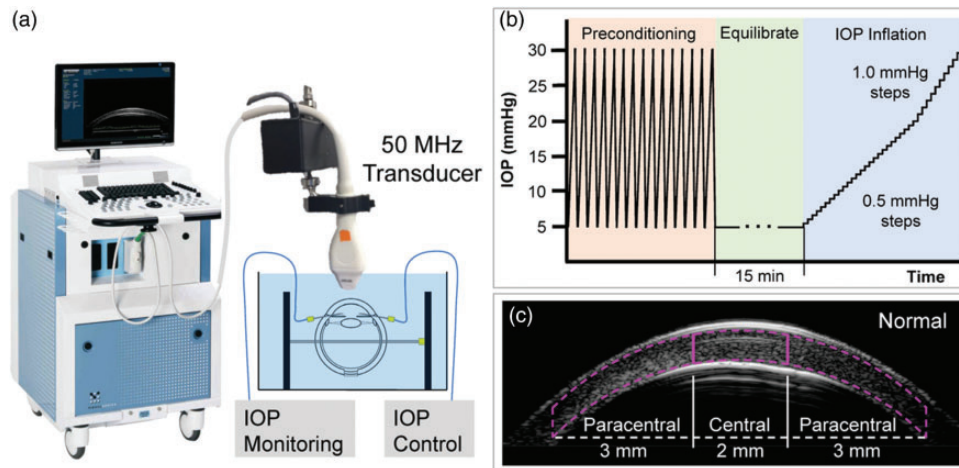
Experimental setup for high-frequency ultrasound imaging of corneal deformation during IOP elevation. (a) Globes were immersed in P188/PBS solution with IOP control and monitoring. (b) Testing protocol for inflating donor eyes from 5 to 30 mmHg. (c) Segmentation of central and paracentral regions of corneal stroma. (A color version of this figure is available in the online journal.)
